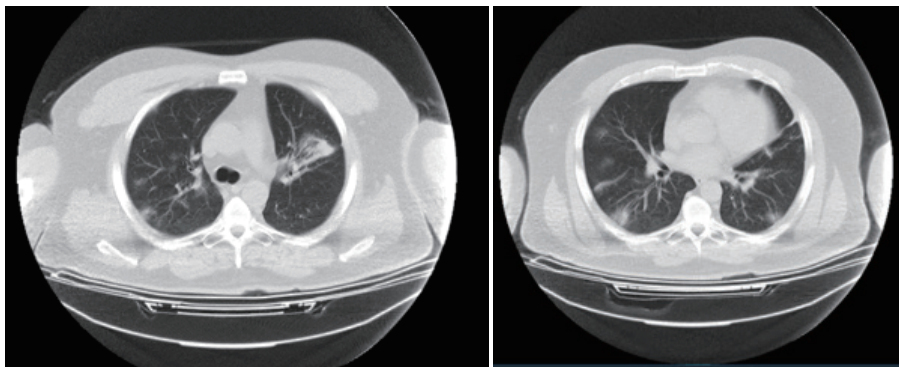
First and second thoracic CT images of case 3 taken after clinical worsening. The first thorax CT was evaluated within normal limits, and the second thorax CT showed a frosted glass image in the bilateral posterior regions
